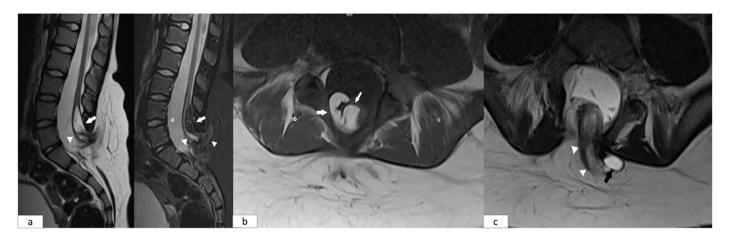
(a) Sagittal T2-weighted magnetic resonance image demonstrates a posterior arch fusion defect of the L5 vertebra and inferior levels. (b) Sagittal T2 fat-suppressed magnetic resonance image reveals subcutaneous fat tissue thickening consisting of lipomyelomeningoceles at the L4-S3 vertebral levels posteriorly (white arrows). (c) Axial T1-weighted magnetic resonance image shows the fat component extending into the right neural foramen at the S1 level (white arrows) and the cystic lesion in the posterior elements of the L5 vertebra (black arrow).
